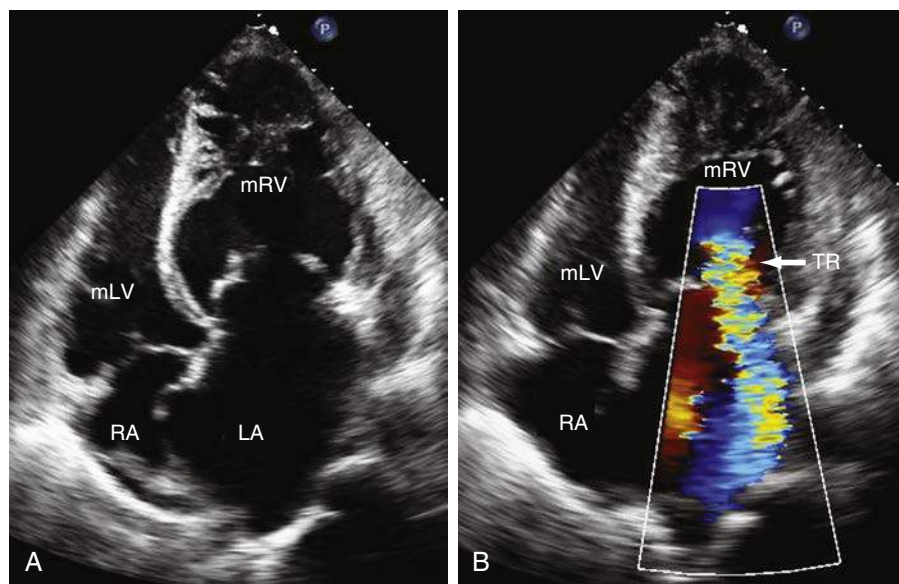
A, Transthoracic echocardiography of the apical four-chamber view in a patient with (corrected) congenital transposition of the great arteries (TGA). B, Color Doppler shows the tricuspid regurgitation jet (white arrow). LA, Left atrium; mLV, morphologic left ventricle; mRV, morphologic right ventricle; RA, right atrium; TR, tricuspid regurgitation.
